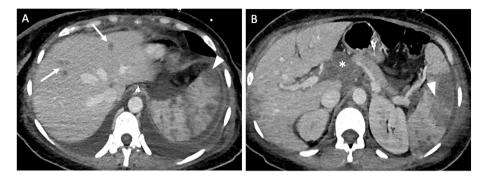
Hepatosplenic tuberculosis in a young female with newly diagnosed HIV. A and B) Contrast-enhanced CT demonstrates hypo-enhancing nodules of variable size in the liver (arrows) and spleen (arrowheads). Periportal necrotic lymph nodes are also evident (asterisk). Bilateral pleural effusion and small volume ascites are present.
